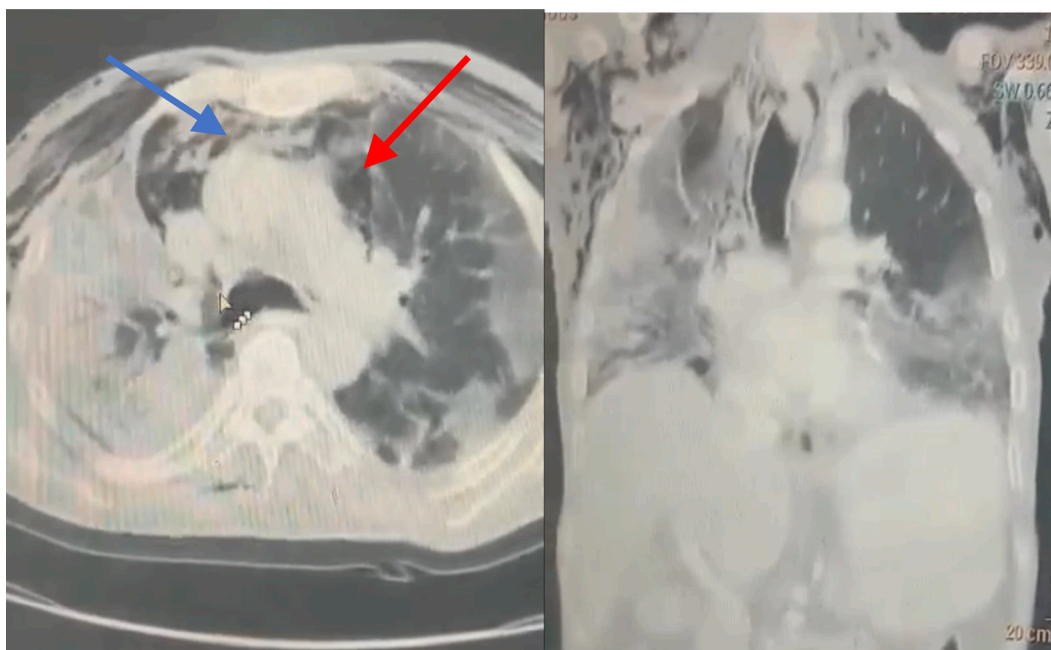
Axial and coronal views, CT scan of chest showed: subcutaneous emphysema + pneumomediastinum and bilateral opacity (patchy pneumonia).
